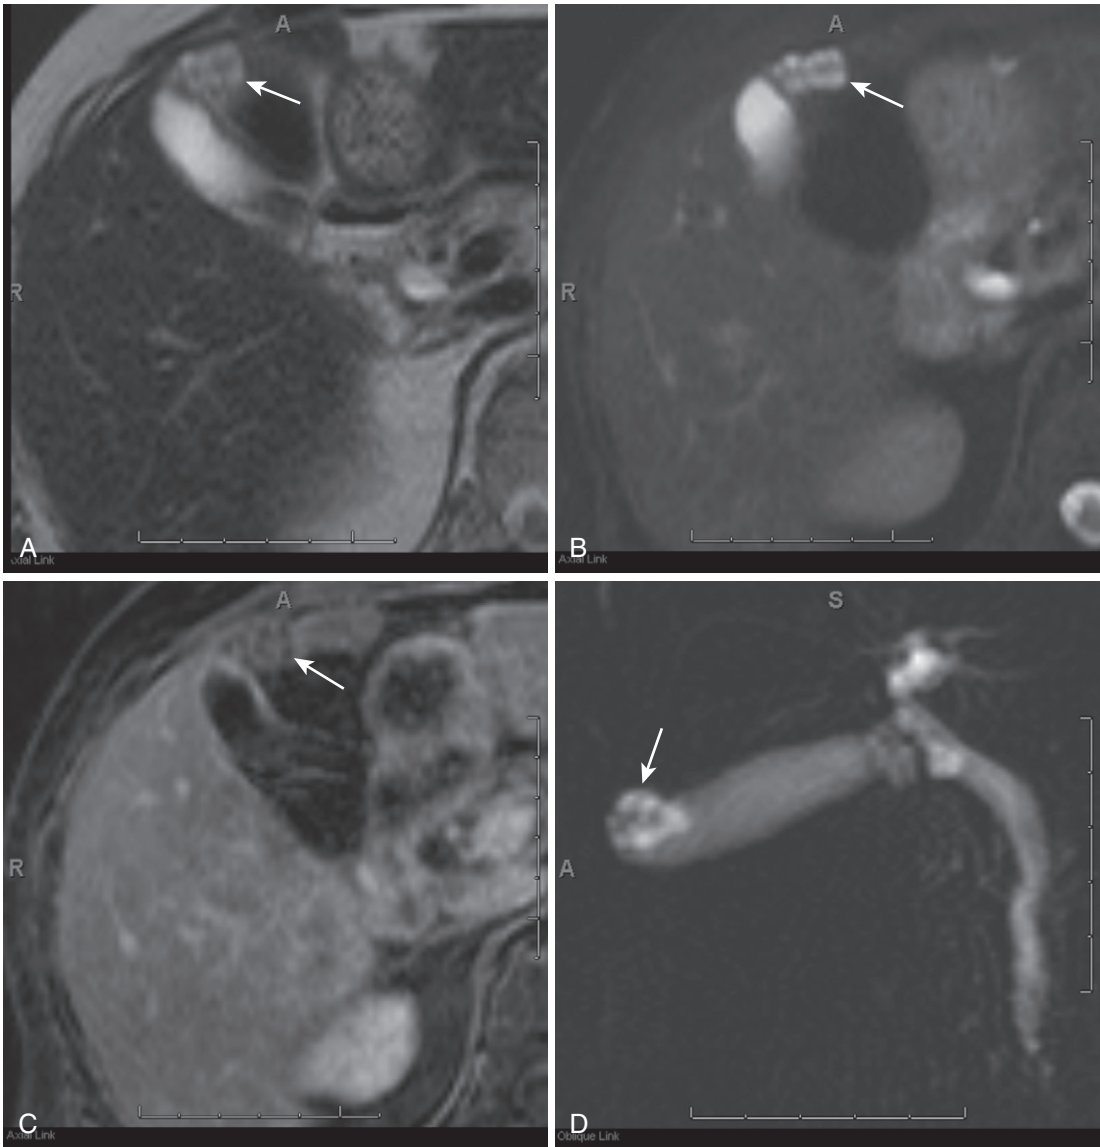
Adenyomyomatosis. T2-weighted (A), fat-suppressed T2-weighted (B), postcontrast fat-suppressed T1-weighted gradient recalled-echo (C), and coronal thick-slab MIP MRCP (D) images demonstrate a cluster of cystic structures at the fundus of the gallbladder (*arrow*), corresponding to multiple intramural diverticula (Rokitansky-Aschoff sinuses) of adenyomyomatosis.
